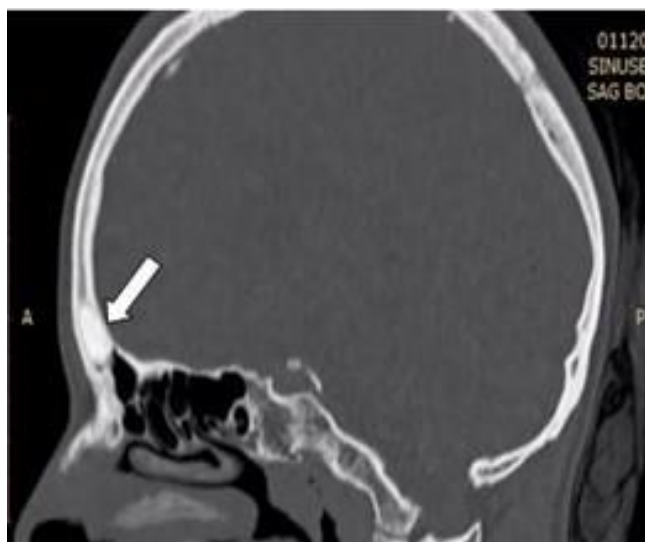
Sagittal view of a CT scan showing osteoid osteoma in right and frontal Frontal sinuses (white arrow).
